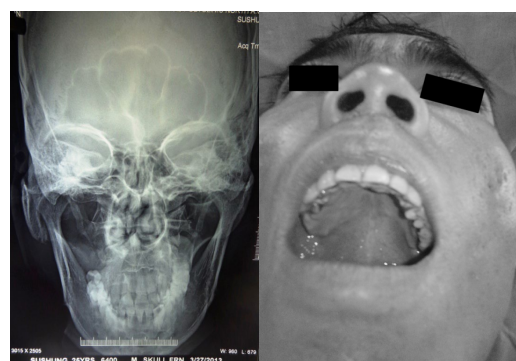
Post operative radiograph and pictures.
